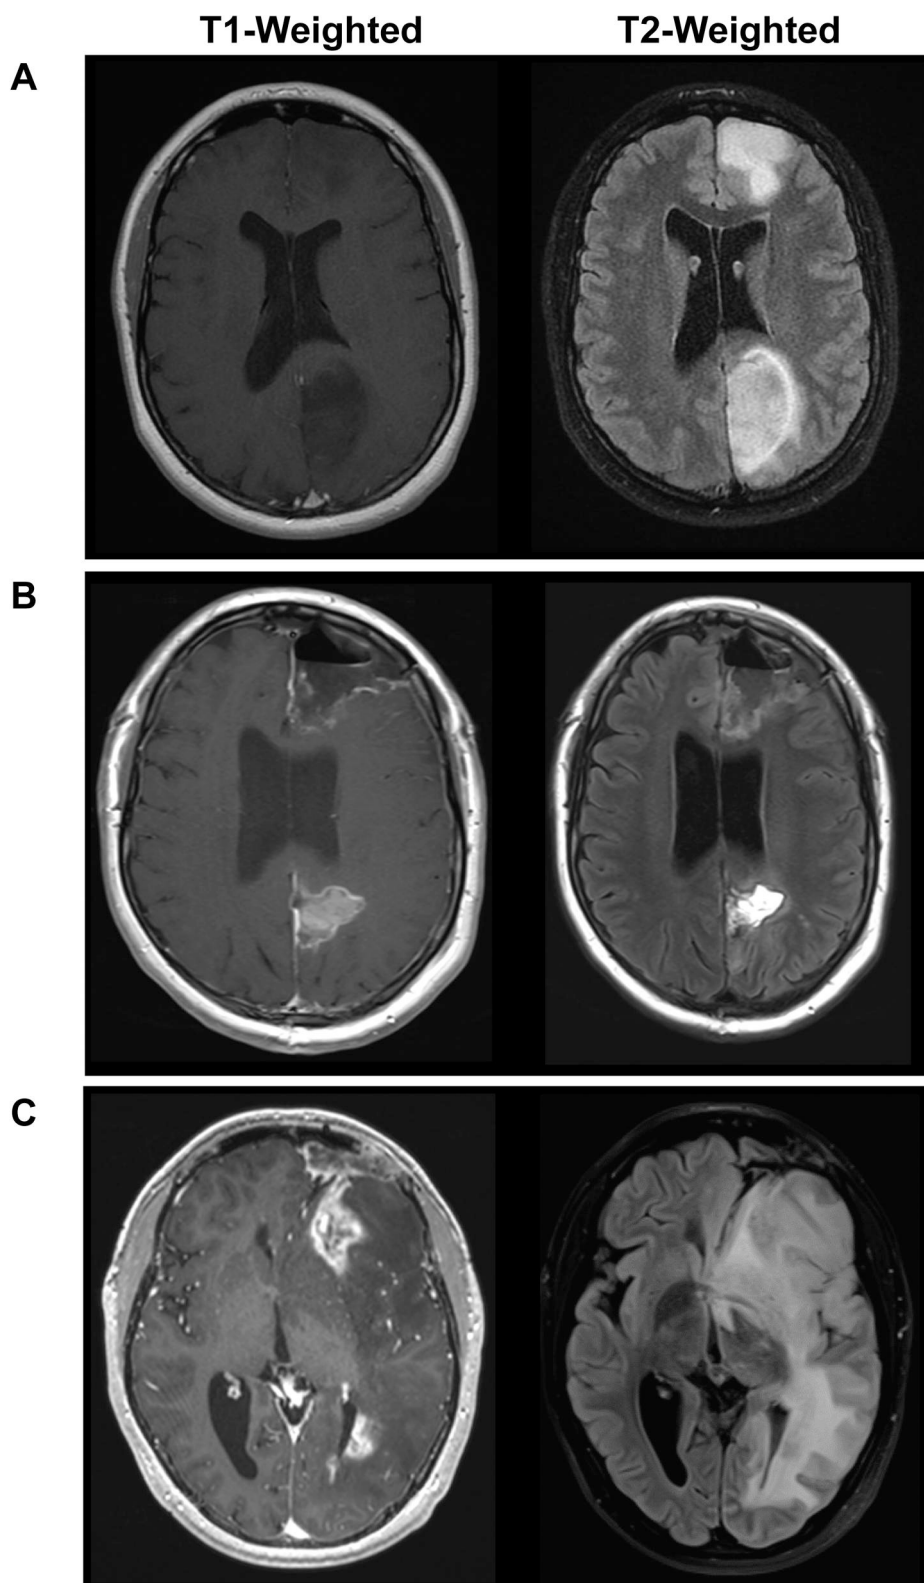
(A) Baseline MRI brain showing two non-enhancing T2 hyperintense lesions in the left frontal and superior parietal lobes. Left: Axial contrast-enhanced T1-weighted sequence. Right: T2-weighted (FLAIR) sequence. (B) Post-operative MRI following resection of the second left frontal tumor. Left: Axial contrast-enhanced T1-weighted sequence. Right: T2-weighted (FLAIR) sequence. (C) MRI brain following six cycles of adjuvant temozolomide. The patient presented acutely with new aphasia and headaches. Left: Axial contrast-enhanced T1-weighted sequence demonstrating increased nodular contrast enhancement in the treated left frontal and left parietal resection cavities. Right: T2-weighted (FLAIR) sequence revealing an expanse in T2 hyperintensity in the left frontal and parietal lobes with corresponding edema and left-to-right midline shift.
